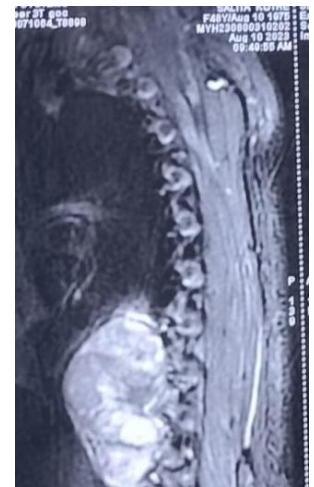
Shows coronal, axial, and lateral view MRI of chest. The tumour is present in posterior mediastinum at right paravertebral D8 to D11 region (pointed by red arrow).
